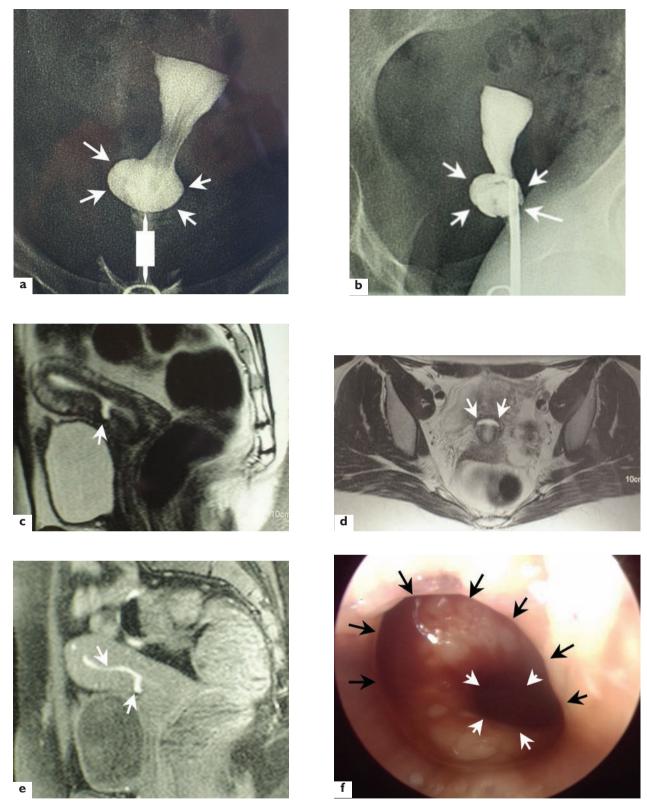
(a and b) In case 2, hysterography revealed wide dehiscence (white arrows) at the level of the cesarean scar. (c) and (d) Sagittal and transverse views (T2-weighted images) confirmed the ultrasound findings: the residual myometrium covering the dehiscence was very thin (white arrows). (e) As in case 1, a T1-weighted image with fatty tissue saturation revealed a hyperintensive signal (white arrows), highly suggestive of old blood retention in the dehiscent scar and the uterine cavity. (f) Hysteroscopic view of the subisthmic area confirmed the presence of old blood retention in the scar. The dehiscent scar (black arrows) is visible from side to side in the anterior wall area. The beginning of the uterine cavity can be seen higher than the scar (white arrows)
